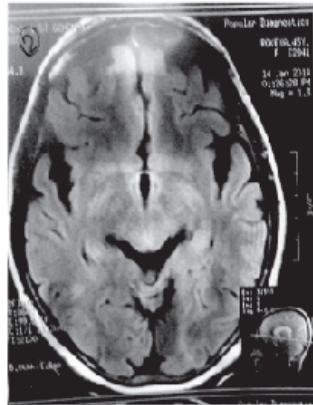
Axial T2 weighted MRI image of the brain, demonstrating asymmetrical frontal and temporal lobe atrophy in the right side.
